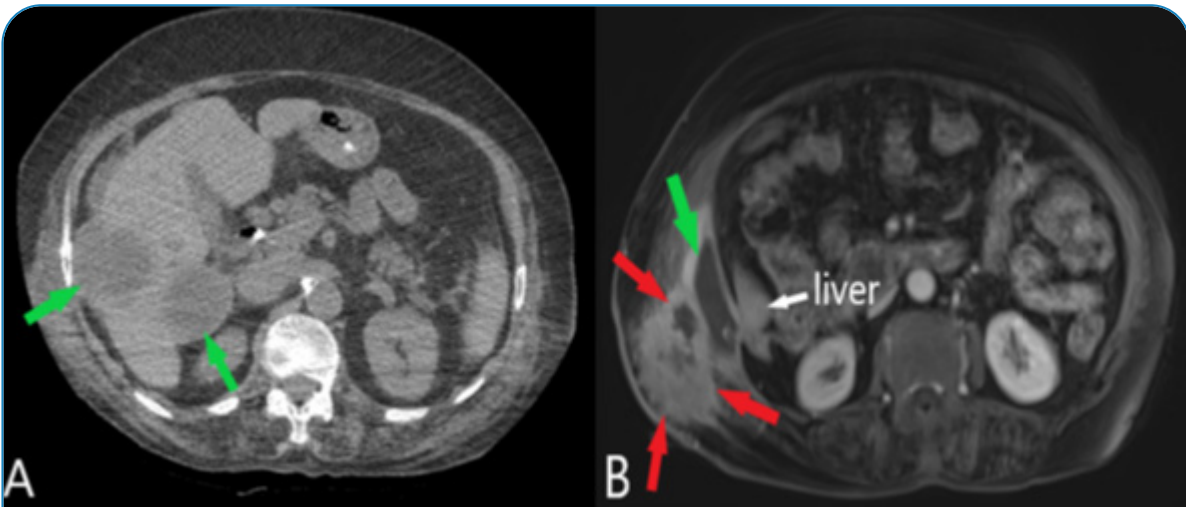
(A) The abdominal computed tomography scan performed 1 year before shows HC lesions in the liver (green arrows). (B) The MRI scan demonstrates a ruptured HC appearance consistent with a previous liver HC lesion in liver segments VI and VII (green arrow). The gadolinium-enhanced MRI scan shows a peripherally enhanced ruptured HC appearance consistent with abscess formation and accompanying soft tissue infection and fistulization (red arrows).
